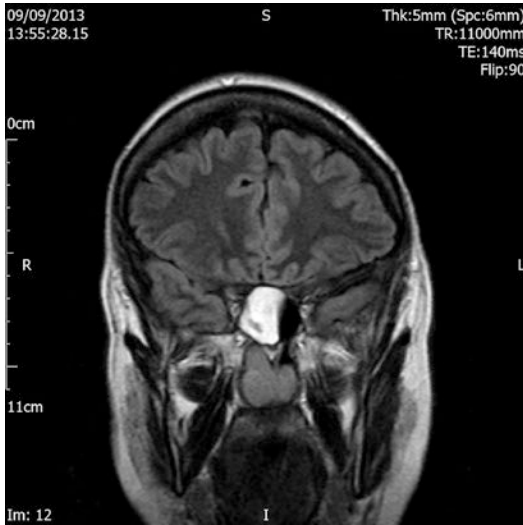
Coronal T2-weighted MRI of the paranasal sinuses demonstrating a hyperintense lesion in the right sphenoid sinus, consistent with a mucocele
